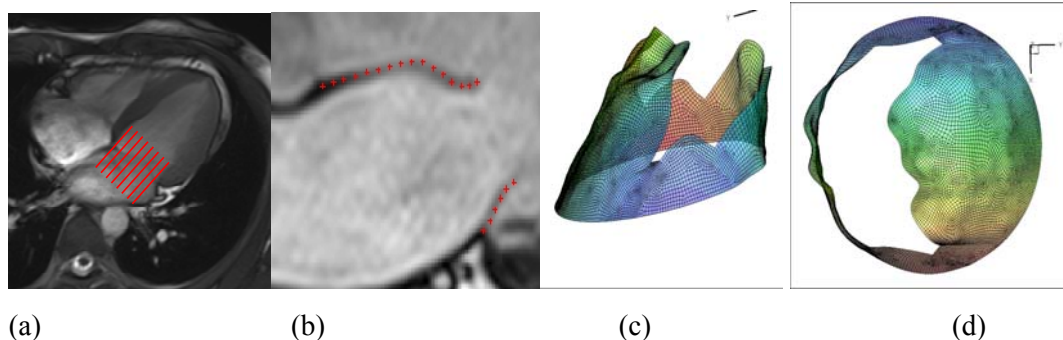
(a), (b): MR images of in-vivo MV; (c), (d) reconstructed MV model
